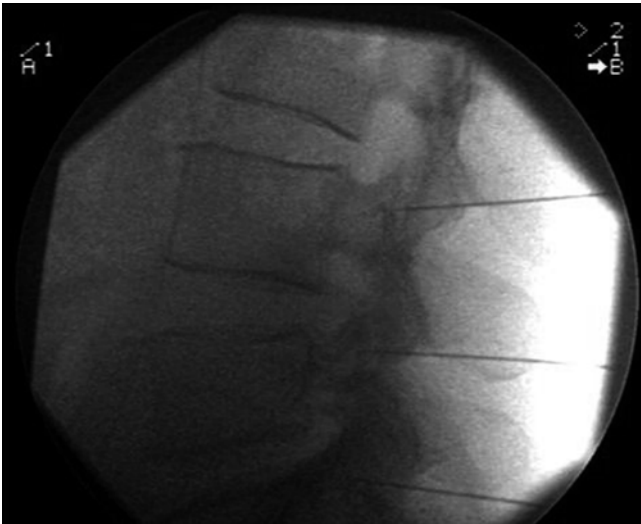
Lumbar facet denervation – X-ray – lateral view
